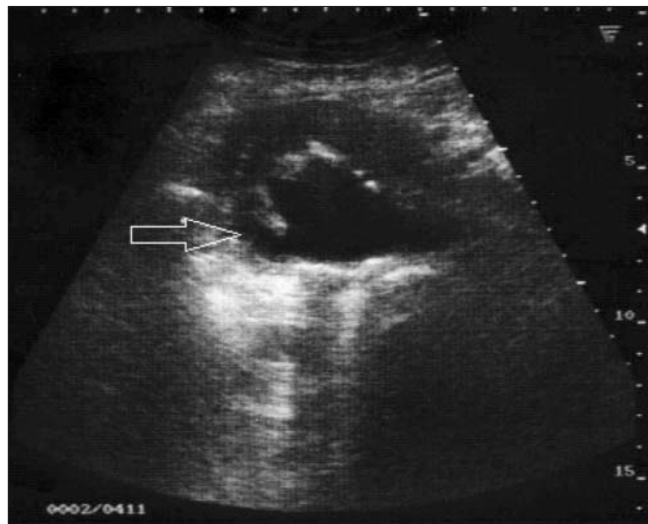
Abdominal ultrasound: aortic aneurysm with right side expansion to the duodenum
